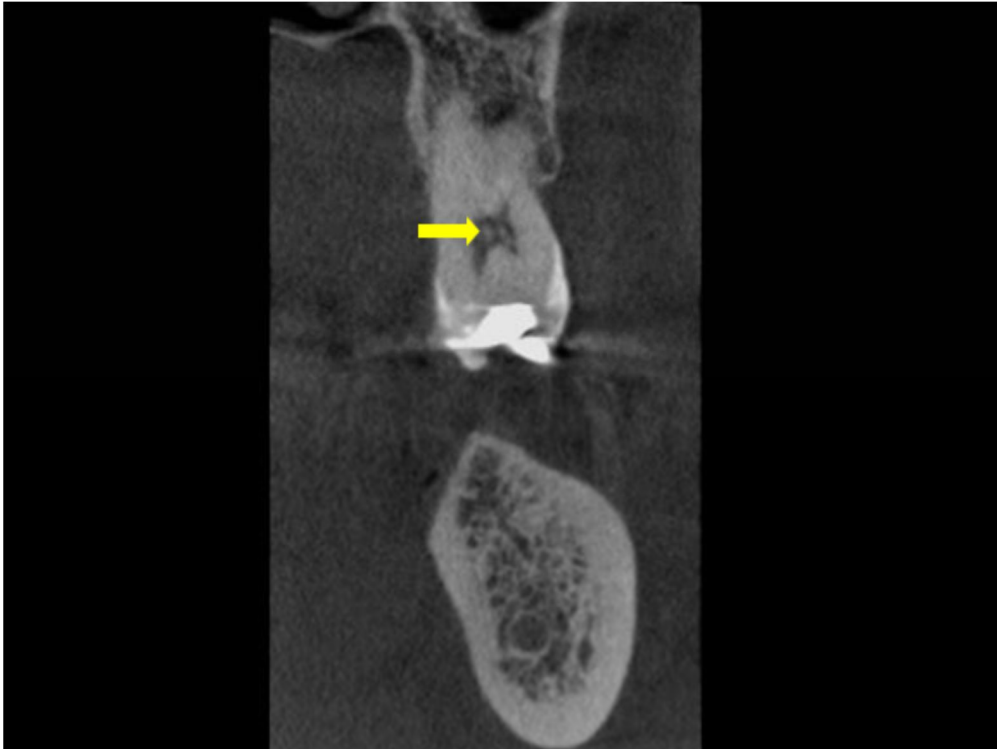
Coronal section of CBCT with pulp stones
